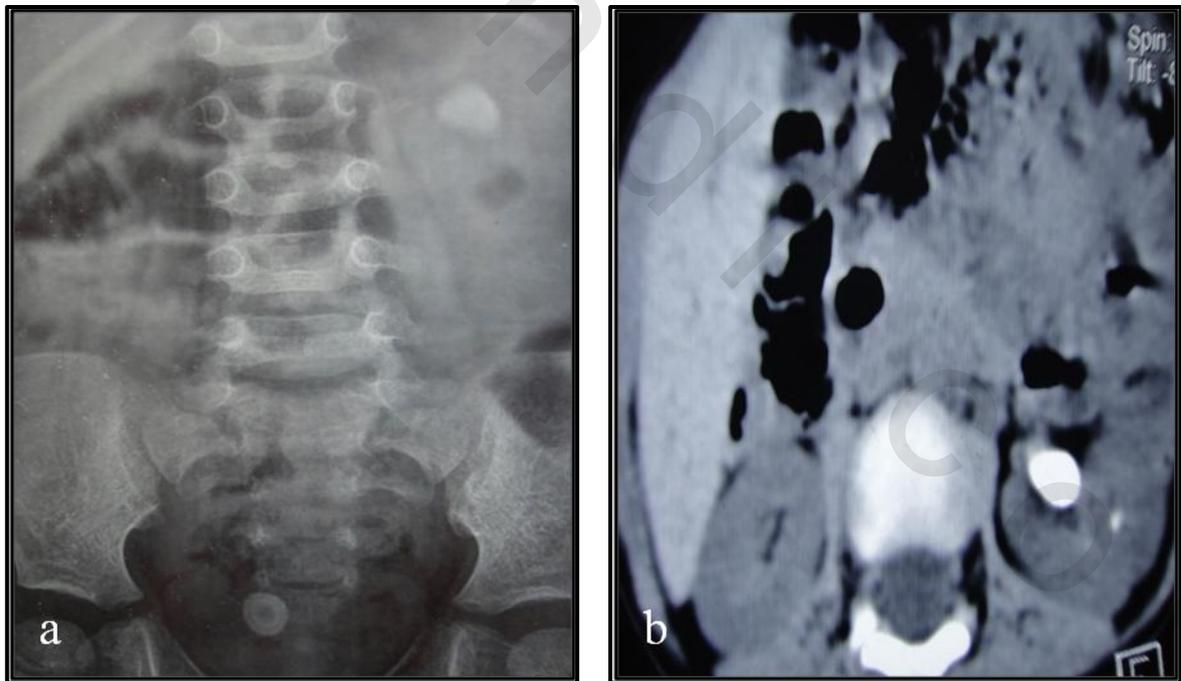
Showing (a) plain KUB (b) multislice CT abdomen and pelvis of 2 years old male child having left renal pelvis stone (20 mm) and urinary bladder stone.
